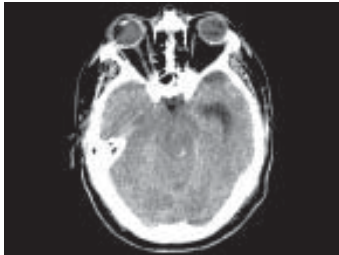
Duret Hemorrhages is essentially a secondary brainstem injury developing subsequent to initial trauma. A CT Brain at level of brainstem shows punctate petechial haemorrhages, central and midline at tegmentum of rostral pons.
